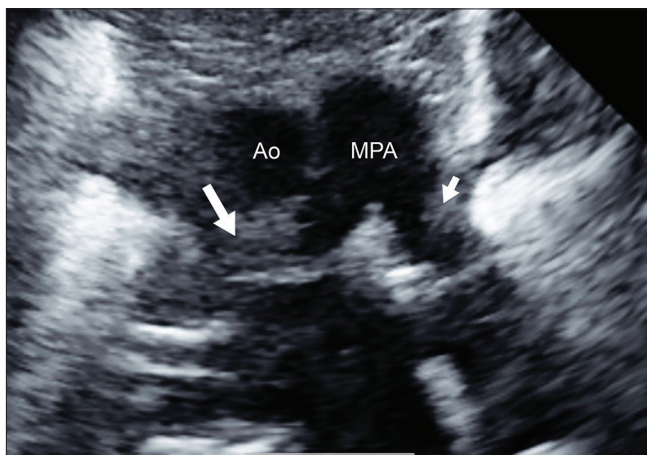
Transthoracic echocardiogram (parasternal view) showing the proximal pulmonary arteries. A large occluding thrombus (long arrow) is seen in the right pulmonary artery, whereas a smaller thrombus (short arrow) is seen in the left pulmonary artery. Ao: Aorta, MPA: Main pulmonary artery
